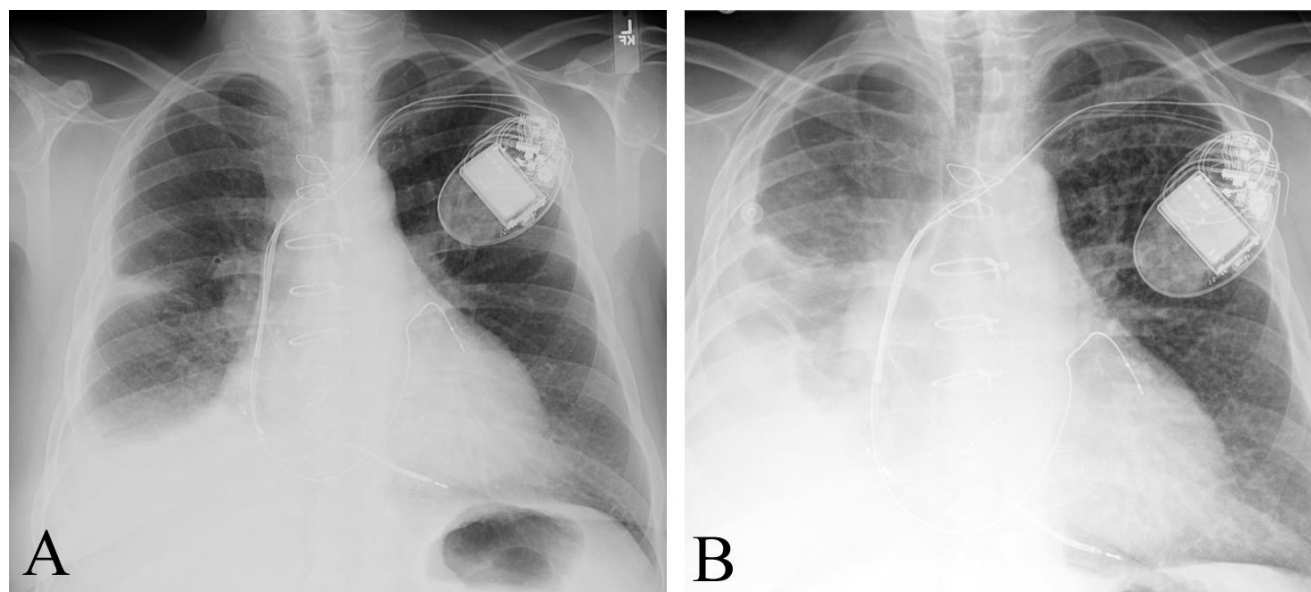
Worsening of congestive heart failure in a 66 year old woman with shortness of breath and a 15 pound weight gain over the past week. A. Baseline PA chest radiograph shows cardiomegaly, a pacer, and a right pleural effusion. B. PA chest at the time of weight gain shows a larger pleural effusion, increased size of pulmonary vessels from pulmonary venous hypertension, and increased lung density from pulmonary edema.
